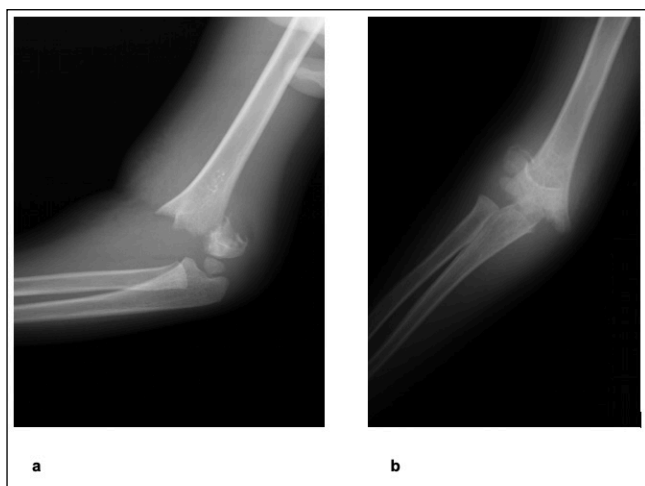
Preoperative A-P radiography of pediatric supracondylar humerus fracture, b: Preoperative lateral radiography of pediatric supracondylar humerus fracture.
